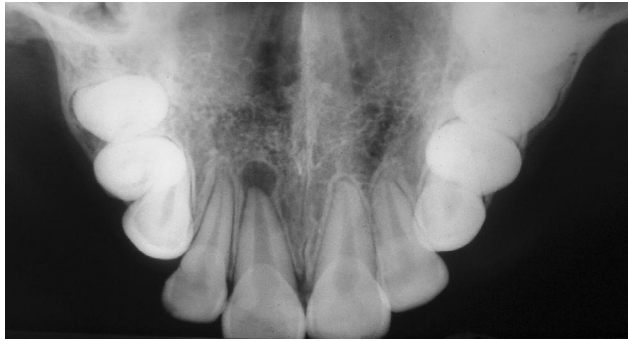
Maxillary occlusal radiograph showing rarefaction of the alveolar bone in the region of maxillary incisors. Well defined periapical granuloma in the region of maxillary right central incisor.
